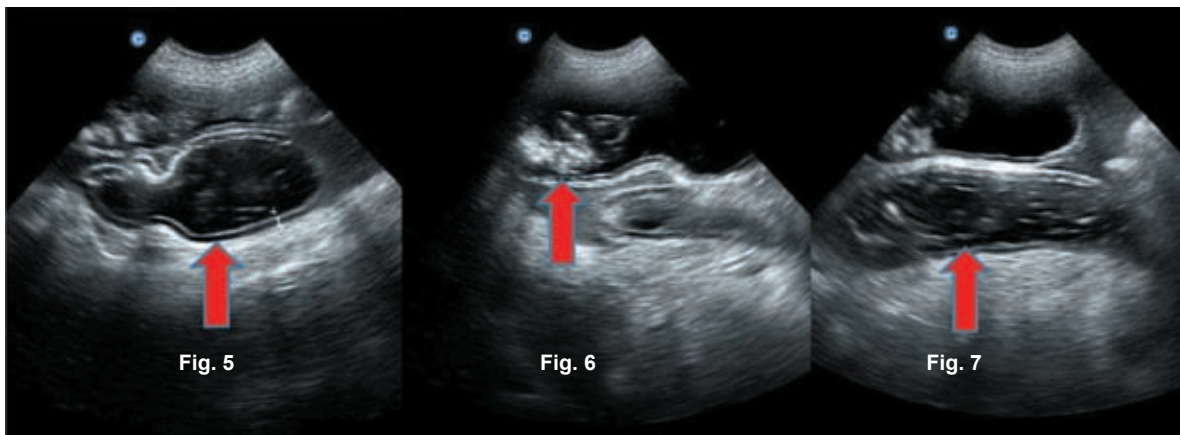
Dilated and sonographically enhanced visualisation of intestinal loop with PEG. Fig.6 - Enhanced visualisation of fluid-foreign body interface in intestinal lumen. Fig.7 - Dilated loops with stagnant pool of PEG
